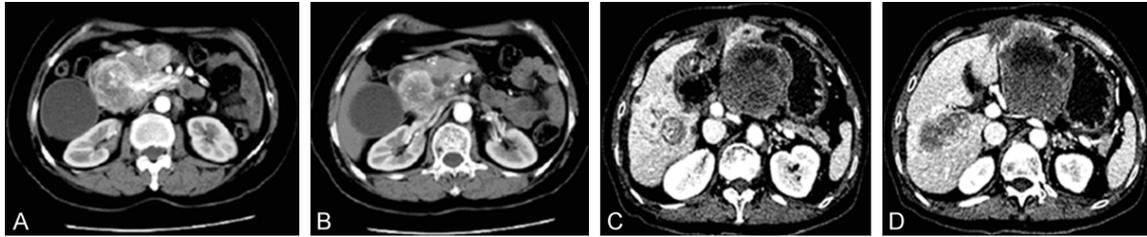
A and B: CT scan in 2002 showed the presence of a 5 cm solid tumor located in the descending part of duodenal, which was adjacent to vater's ampullary and enhanced inhomogeneously. C and D: CT revealing multifocal heterogeneous mass in bilateral lobes of liver, ranging from 1-15 cm in diameter in bilateral lobes of liver.
